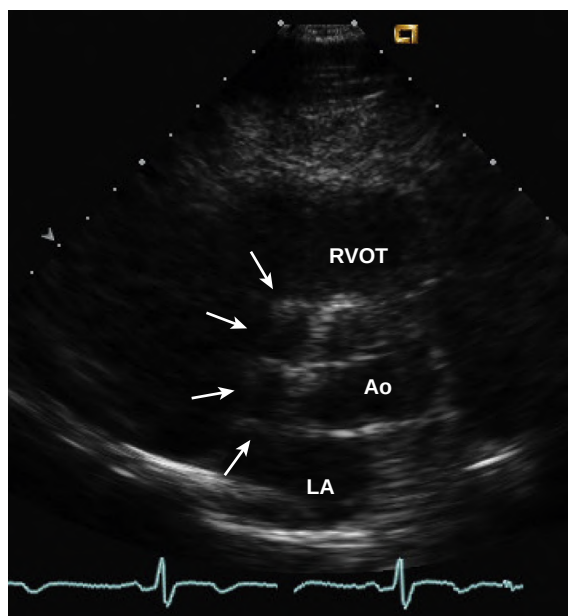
Refraction artifact. In this parasternal short-axis image of the aortic valve (Ao), a refraction artifact results in the appearance of a "second" aortic valve (arrows), partly overlapping with the actual position of the aortic valve. RVOT, Right ventricular outflow tract.
